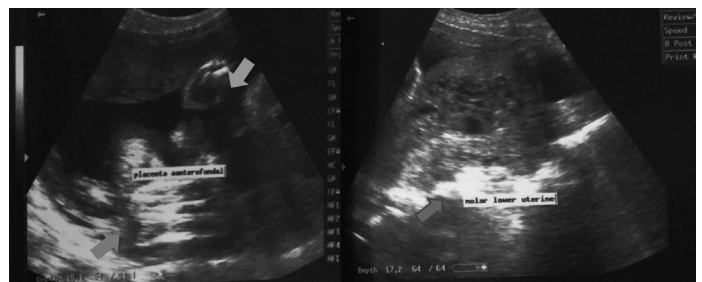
Ultrasound report on admission showing a live fetus (light gray arrow), hydatidiform mole (dark gray arrow) located at the lower uterine with a grape-like appearance, normal placenta (semi light gray arrow) located at the fundal area
